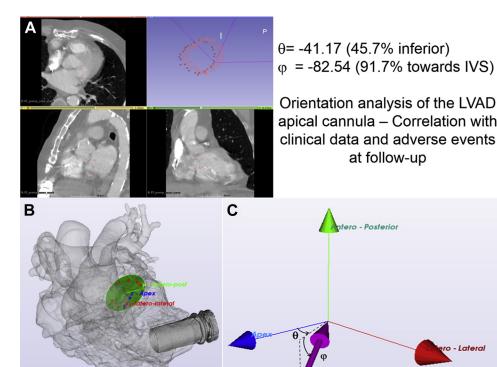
(A) Screenshot of an LVAD implantation preoperative planning and postoperative analysis tool: definition of the mitral annulus by the user on post-implantation CT scan. (B) Three-dimensional representation of the cardiac chambers after segmentation with the obtained mitral orifice plane. (C) Coordinates system for the LVAD apical cannula orientation with respect to the mitral valvular orifice; description through angles θ and ϕ for quantification of displacement from ideal orientation. IVS = interventricular septum. (Color version of figure is available online.)
